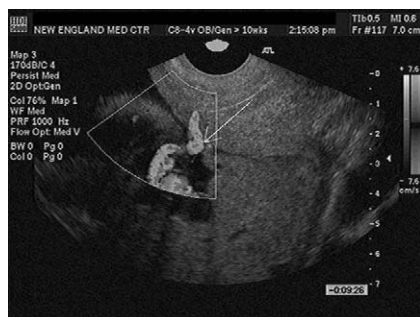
Color Doppler demonstrating the presence of fetal vessels above the internal os (arrow).
